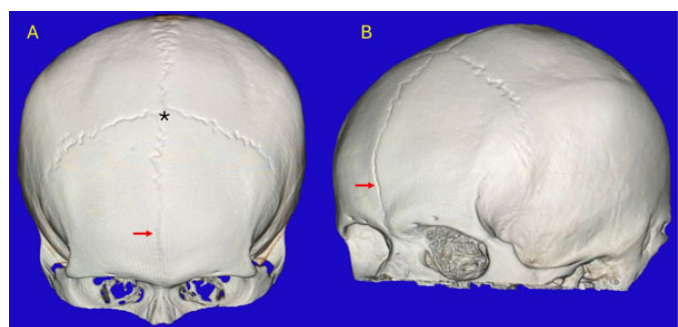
Computed axial tomography (CT) image of the skull and 3D reconstruction, where the persistence of the metopic suture is observed. (A) Anterior view and (B) Left oblique view. The asterisk indicates the anterior fontanel (bregma), and the arrow indicates the future metopic suture.
